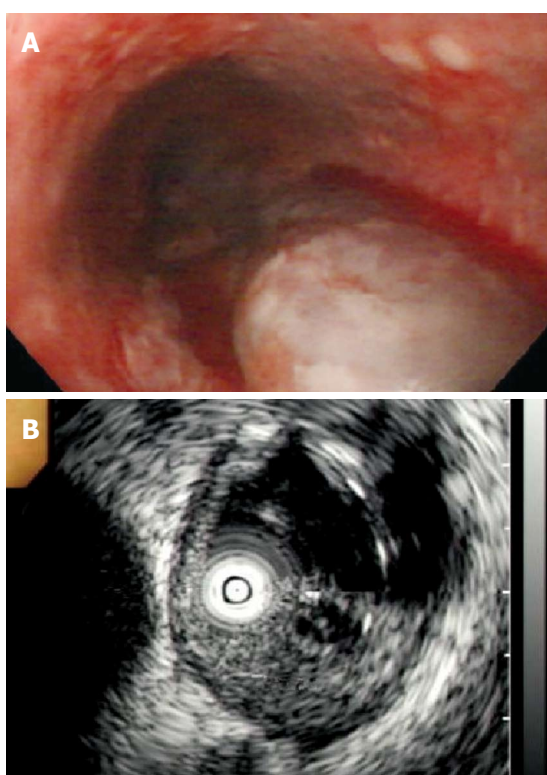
Esophagogastroduodenoscopy revealing a purplish bleeding esophageal submucosal tumor (A) and endoscopic ultrasound revealing a mixed echoic tumor with an anechoic component and an irregular at the submucosal layer (B).
